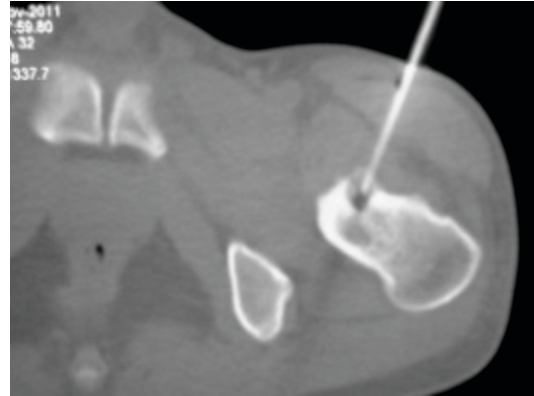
A & B: Percutaneous RF ablation of osteoid osteoma. After placement of bone biopsy needle into the lesion under CT guidance the stylet was withdrawn and the RF probe was introduced (A). Axial CT image at the time of procedure (B) showing tip of the biopsy needle in the lesion.
